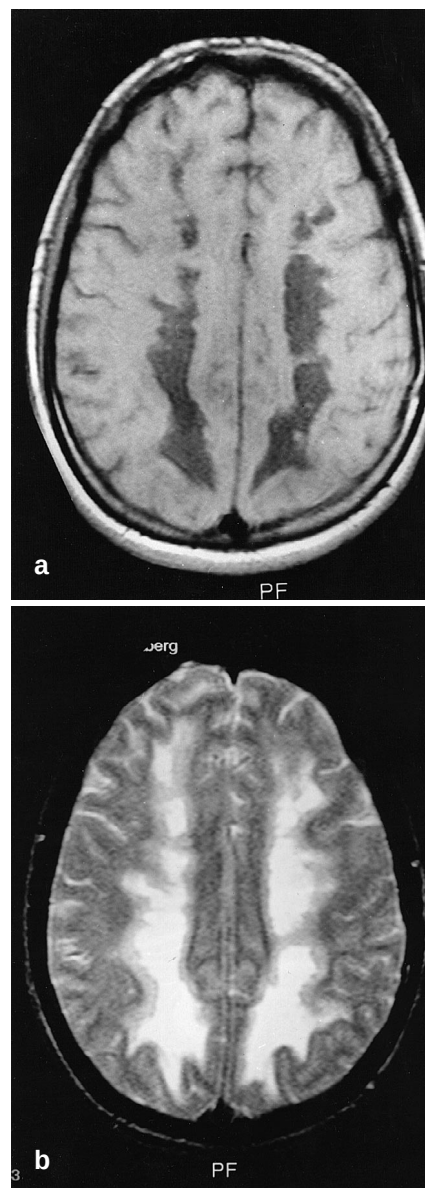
a T1-weighted magnetic resonance image in the transverse plane shows bilateral, symmetric, low signal intensity of the white matter. The abnormalities are similar to those found on CT (Fig. 1). b T2-weighted image shows a high signal in the corresponding area. There is no tissue swelling indicating that the signal changes are due to abnormalities in the white matter and not due to brain edema. There is no loss of gray matter
